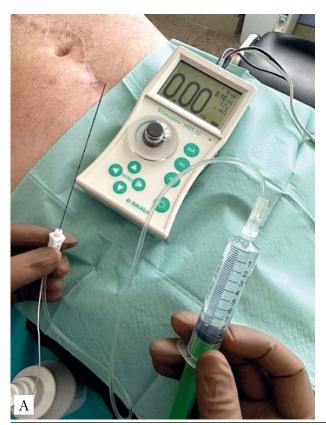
Photo of BTA administration into the muscles of the anterior abdominal wall: A — equipment for BTA injections (needle, neurostimulator, and syringe with BTA); B — view of the one-point BTA injection under the ultrasound control
